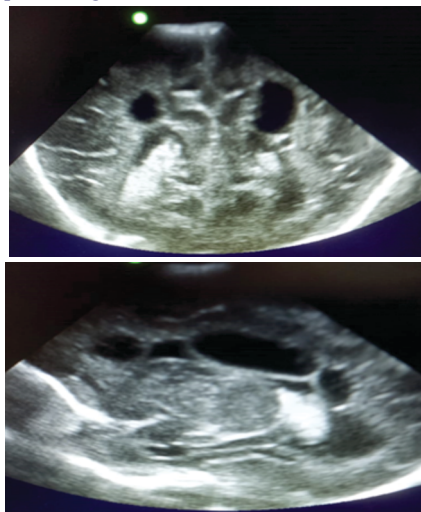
Coronal and sagittal images of neurosonogram depict multiple variable sized cystic areas predominantly in anterior periventricular regions (Grade-III Periventricular Leukomalacia), also note the increased periventricular echogenicity (Grade-I Periventricular Leukomalacia)
